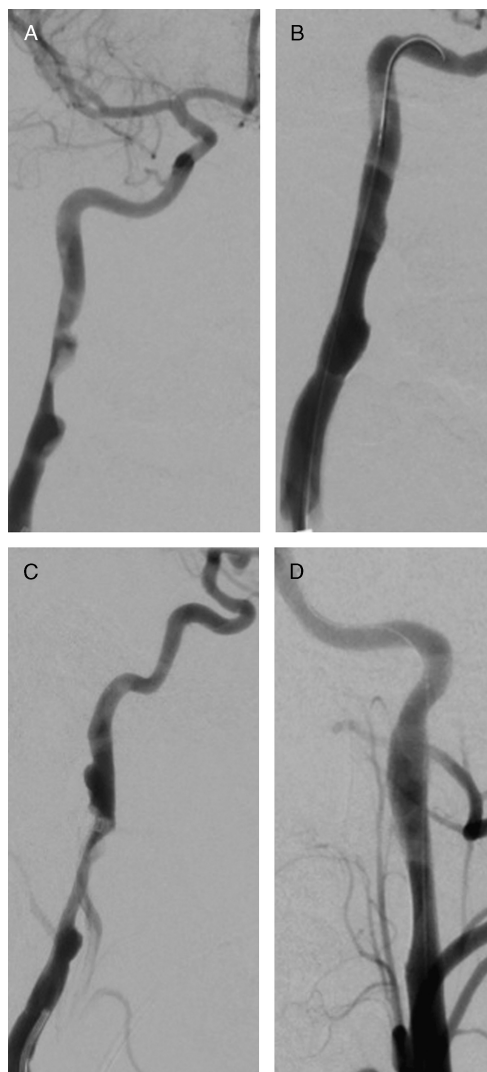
A 24-year-old patient after a motor vehicle collision presented with bilateral cervical ICA injuries and head CT evidence of small bilateral multifocal infarctions (not shown). *A*, Left anterior oblique projection DSA image of the right ICA on posttrauma Day 4 demonstrates traumatic cervical ICA dissection-related narrowing, associated dissecting aneurysm, and probable intraluminal thrombus. *B*, Left anterior oblique DSA of the right ICA immediately after stent reconstruction demonstrates patency of the ICA with some residual aneurysmal irregularity of the midcervical ICA. *C*, Lateral projection DSA image of the left ICA demonstrates traumatic cervical left ICA dissection-related narrowing and associated dissecting aneurysms. *D*, Anteroposterior DSA image of the left ICA immediately after stent reconstruction demonstrates patency of the ICA with mild residual vessel irregularity of the midcervical left ICA. The patient continues to recover from infarctions experienced before stent repair and has minor neurologic deficits 1 month after procedure. Vessel remodeling may continue to occur on further follow-up imaging (not shown).
